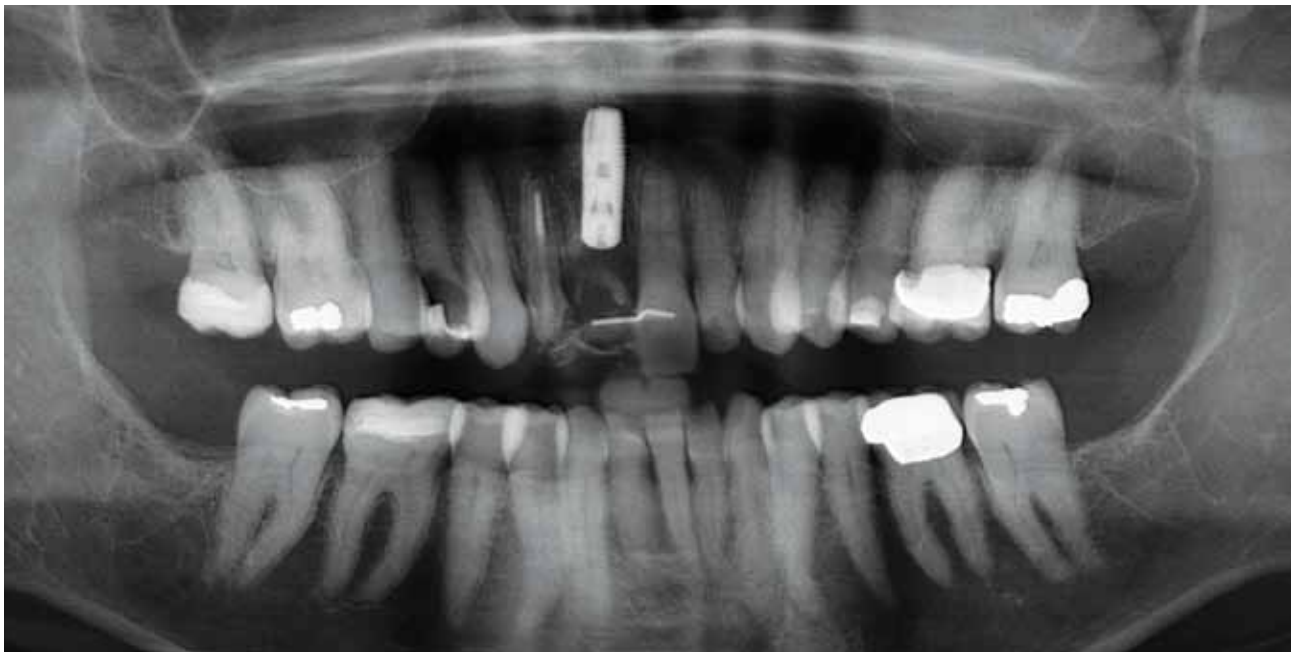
Periapical radiograph showing implant in position.
